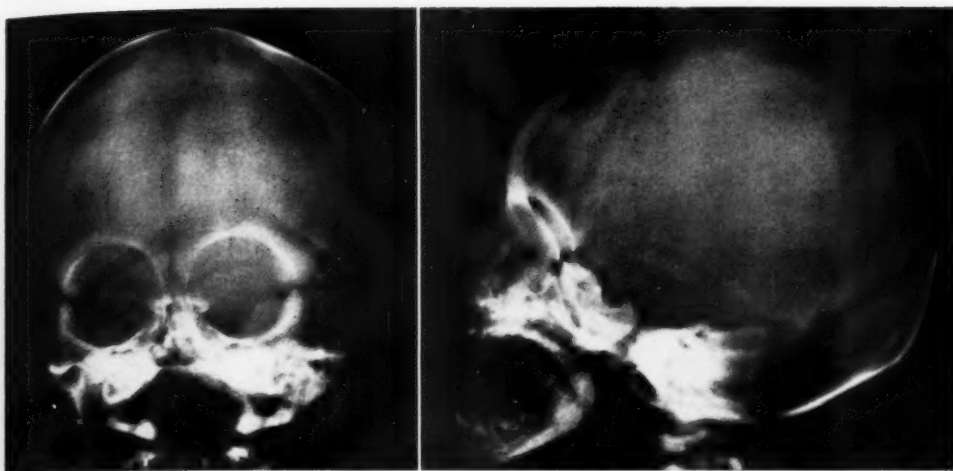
Case I. Anteroposterior and lateral roentgenograms of the skull taken at eight days of age. Note the narrow interorbital distance, the smallness of the anterior cranial fossa, and the open metopic suture.
